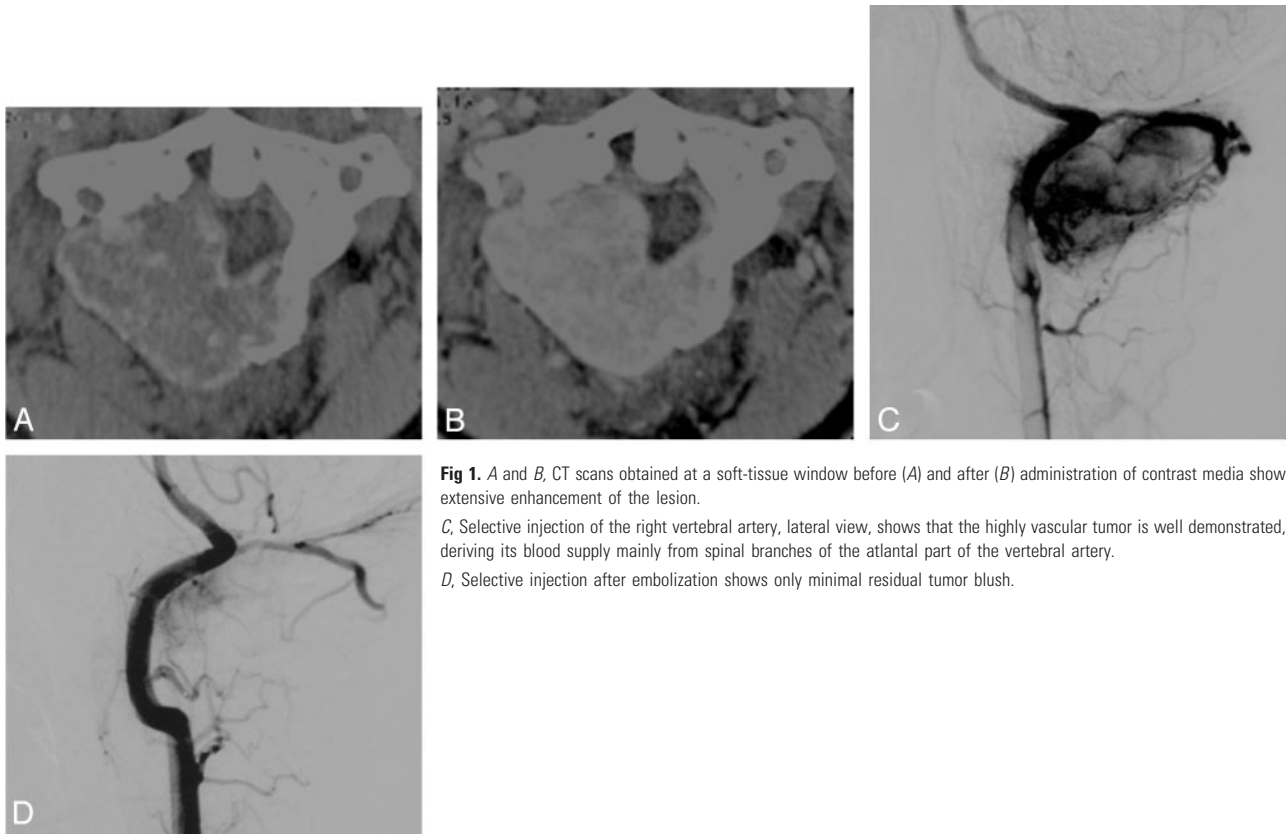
A and B, CT scans obtained at a soft-tissue window before (A) and after (B) administration of contrast media show extensive enhancement of the lesion. C, Selective injection of the right vertebral artery, lateral view, shows that the highly vascular tumor is well demonstrated, deriving its blood supply mainly from spinal branches of the atlantal part of the vertebral artery. D, Selective injection after embolization shows only minimal residual tumor blush.
